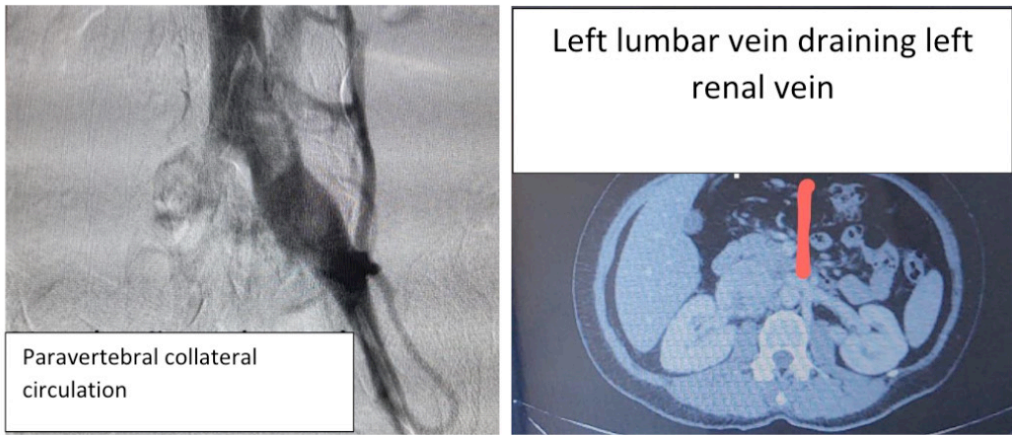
Planning steps: venography and computed tomography for visualization of collateral vasculature.
